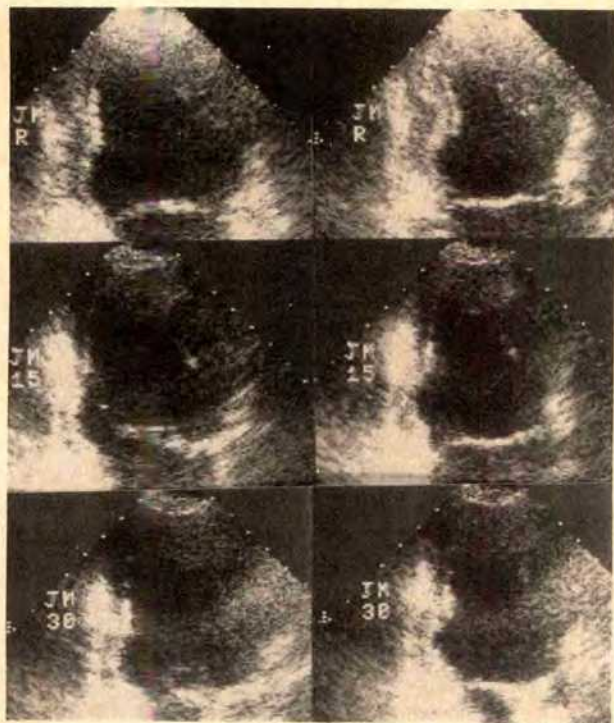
Apical 2-chamber views of a patient with 3-vessel coronary artery disease at rest (top row), and 15 (middle row) and 30 (bottom row) minutes after exercise. Photographs at left represent end diastole and at right end systole. The inferoapical and anterior walls thicken normally at rest with a reduction in left ventricular diameter. Thirty minutes after exercise there is less thickening toward the apical half of the ventricle and the left ventricular diameter appears wider than at rest (compare lower right with upper right figures).
